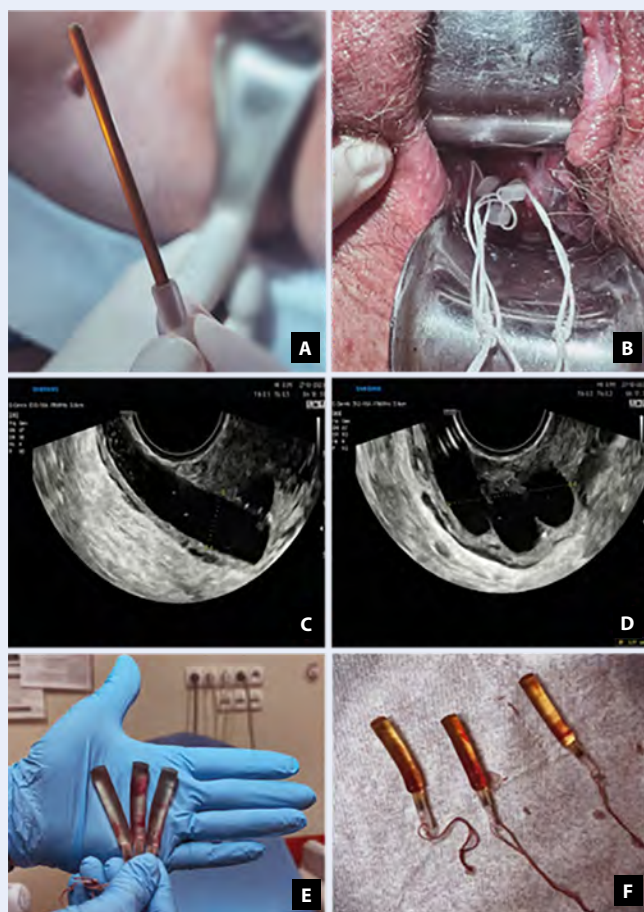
A. Synthetic osmotic cervical dilator (Dilapan-S), B. 3 synthetic osmotic cervical dilators (Dilapan-S) in cervix, C, D. Synthetic osmotic cervical dilators (Dilapan-S) in cervix after 24 h in transvaginal ultrasound, E, F. Synthetic osmotic cervical dilator (Dilapan-S) after 24 h
